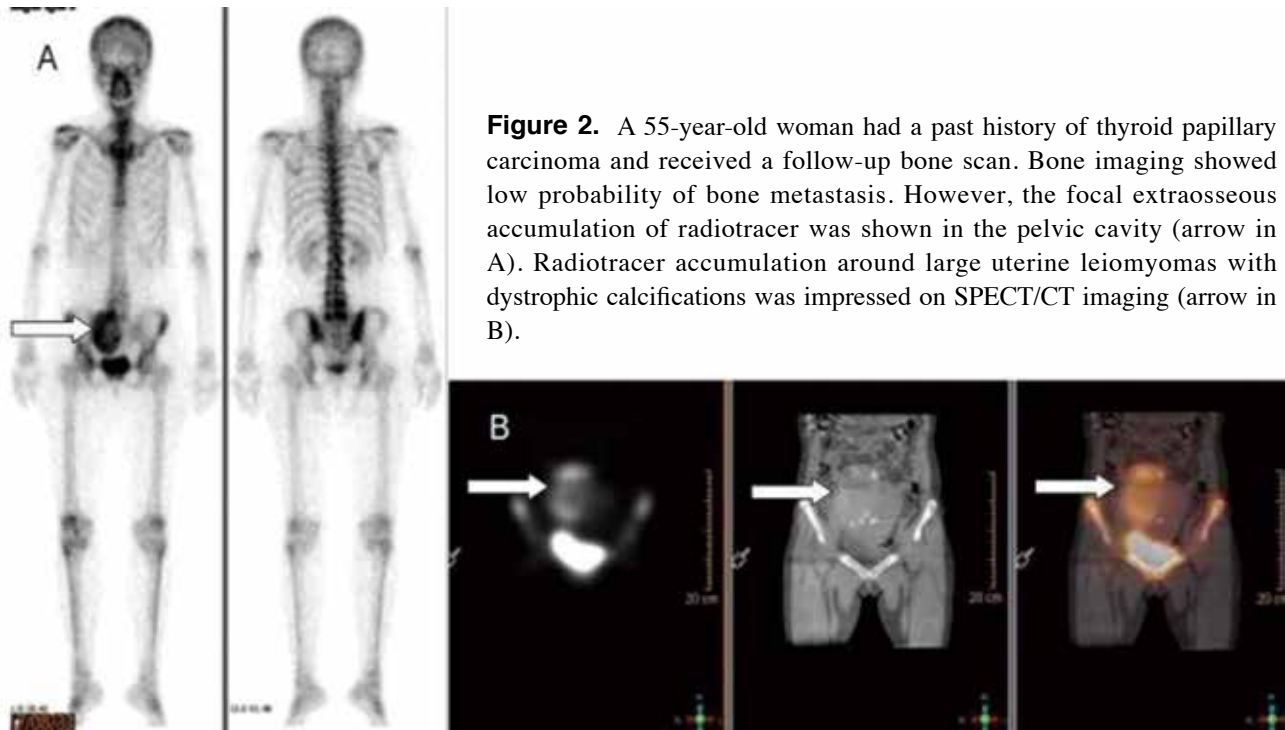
A 55-year-old woman had a past history of thyroid papillary carcinoma and received a follow-up bone scan. Bone imaging showed low probability of bone metastasis. However, the focal extraosseous accumulation of radiotracer was shown in the pelvic cavity (arrow in A). Radiotracer accumulation around large uterine leiomyomas with dystrophic calcifications was impressed on SPECT/CT imaging (arrow in B).
